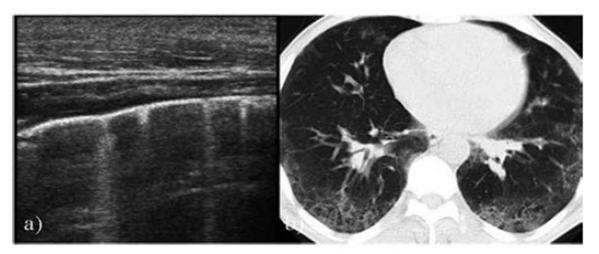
a) The comet tail sign (4 B-lines) in moderate form of alveolo-interstitial involvement in systemic sclerosis. b) HRCT showing moderate form of alveolo-interstitial involvement in systemic sclerosis (Warrick score=14).
